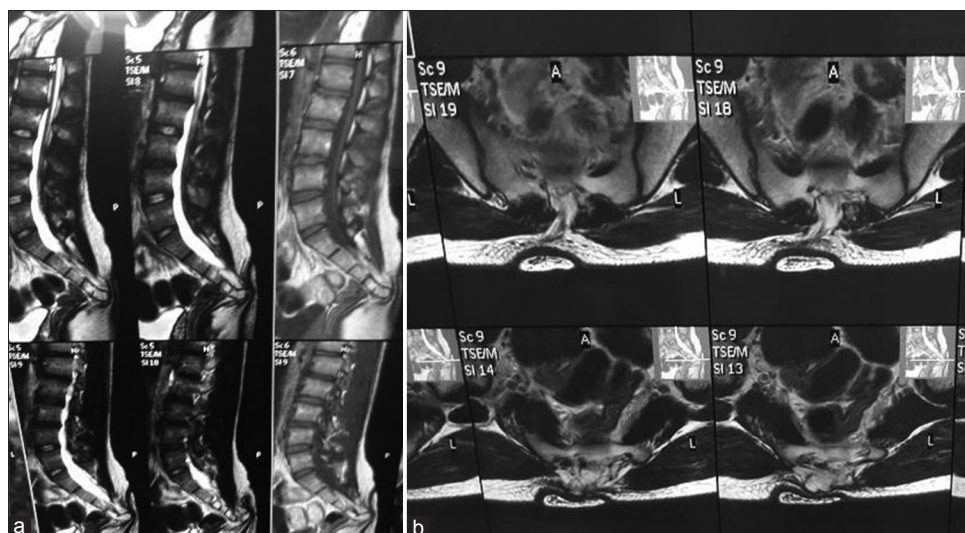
(a) Preoperative sagittal magnetic resonance imaging showing conus lying at L3 and tail arising from sacral region (b) axial magnetic resonance imaging showing spina bifida and fibrous band connecting tail and dura
